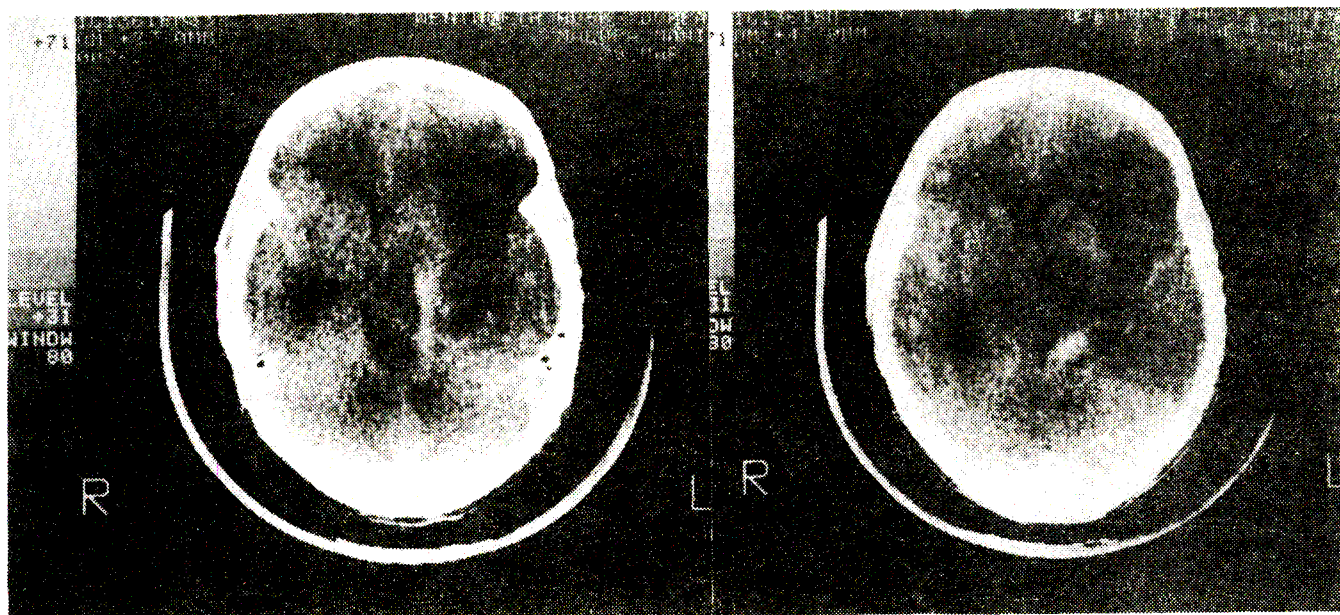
(a,b). CT on day 4 of Nimodipine treatment.
